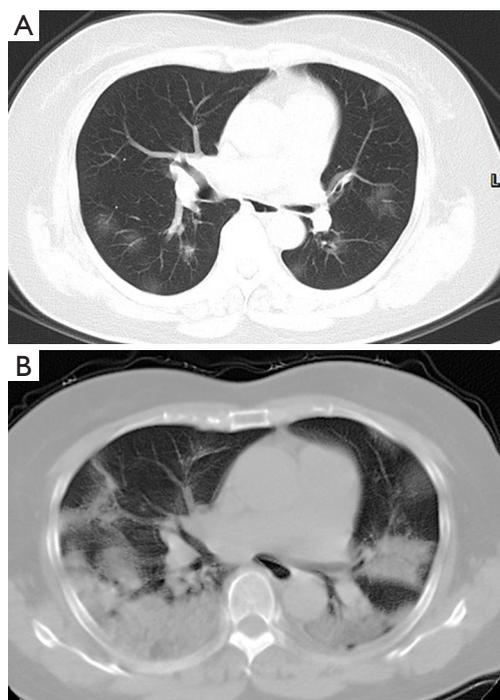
Local and bilateral patchy shadowing in a 63-year-old female with COVID-19. (A) CT image at the initial examination shows small patchy shadows in the peripheral regions of both the lungs. (B) CT taken 5 days later shows apparent progression of disease with increased density areas in both the lungs.
